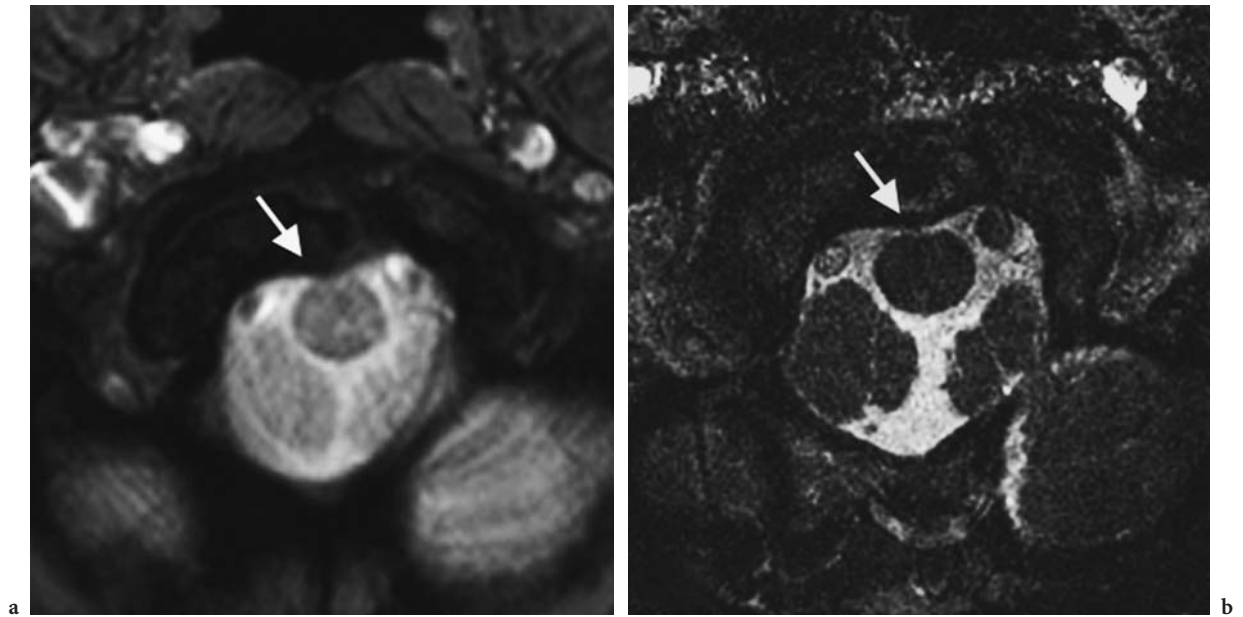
Condylar fracture, callus forming. a Axial T2-weighted MR image. b Axial 3D T2-weighted CISS image. Slight compression of the medulla oblongata due to a fracture of the condylar process with secondary callus formation (arrows)
